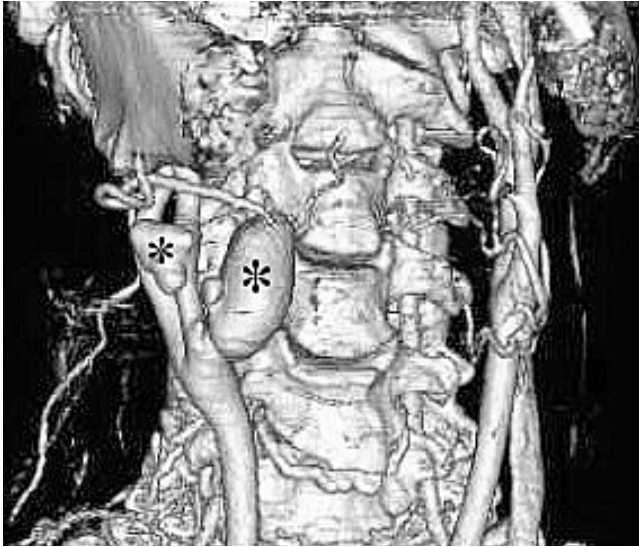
A three-dimensional CT image of two pseudoaneurysms (asterisk) located in the right external carotid artery (ECA).
